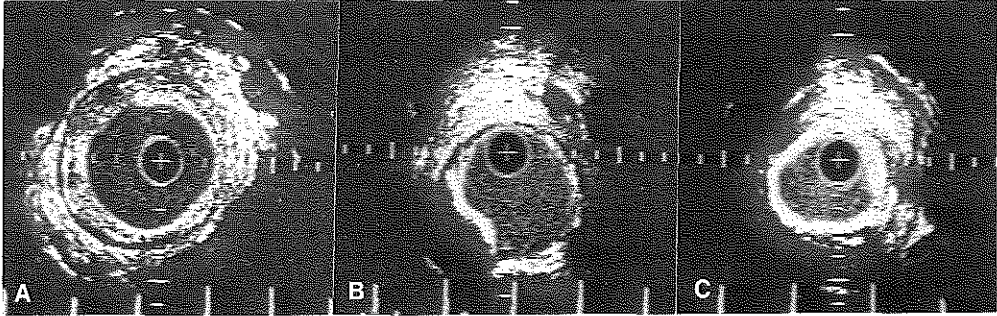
In vivo* echographic images of the superficial femoral artery (30 MHz) obtained at 3 different levels. A, proximally a soft lesion is seen as a diffuse echo bright structure superimposed to the hypoechoic media. B, more distally an eccentric hard lesion is seen as a bright structure casting ultrasonic shadowing. The underlying arterial wall can no longer be seen. C, the hard lesion is now seen affecting the arterial wall circumferentially, resulting in a stenosis. Calibration = 1 mm.
